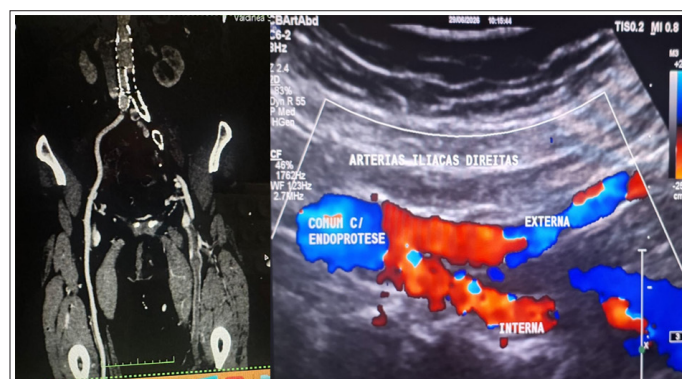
At 11-Month Follow-Up (March 2026), CTA Demonstrated Occlusion of the Left Endograft Limb; However, The Wrapsody® Stent Maintained Patency of the Endograft Body and Right Iliac Axis Demonstrated in Both CTA and Duplex Ultrasound
